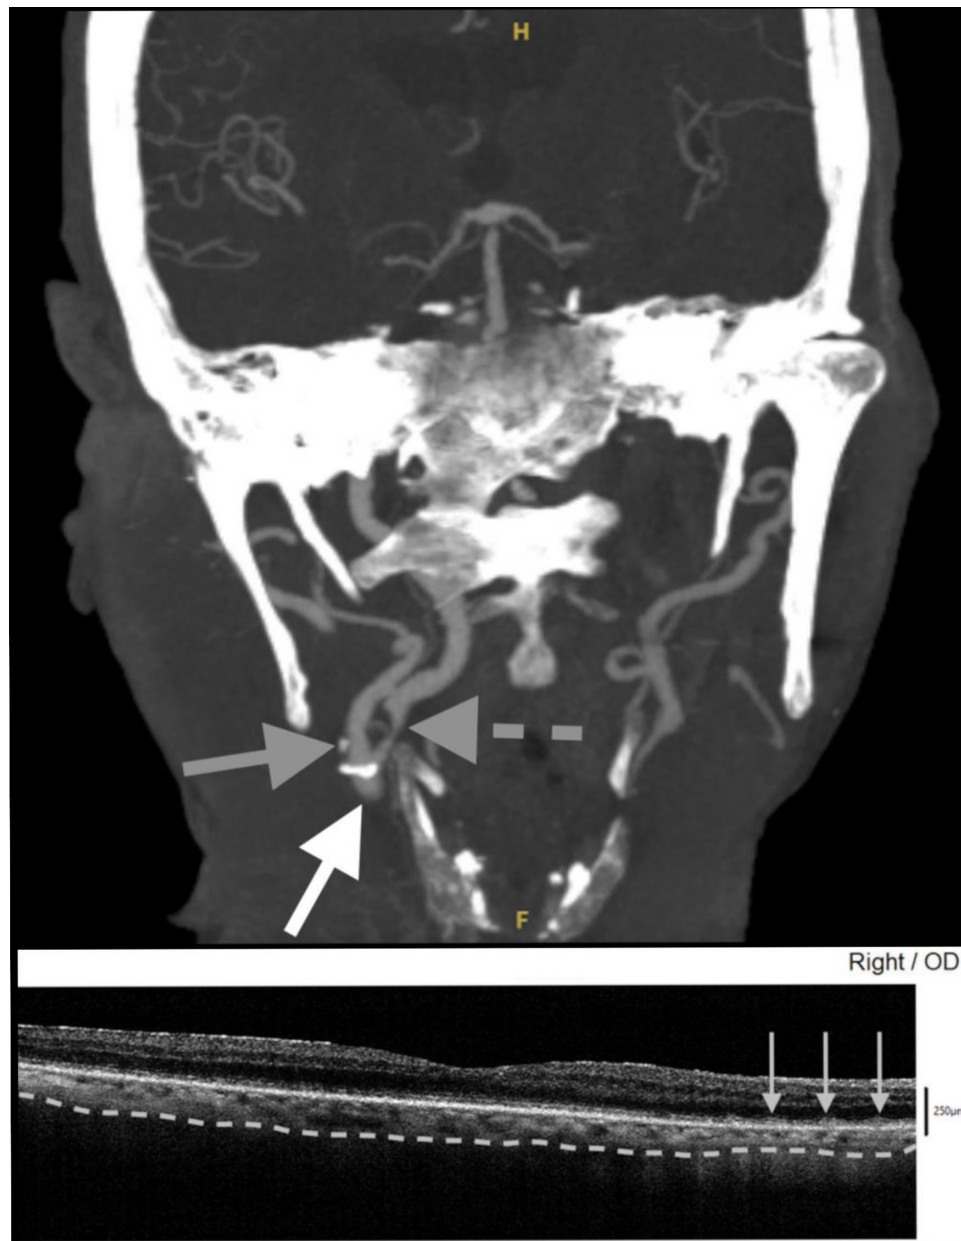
Top image:* CT angiography head and neck of a patient with bilateral ICA stenosis. Severe (70%–89%) right ICA stenosis is shown. Complete (100%) left ICA stenosis is demonstrated in another CT section (not shown). The right common carotid artery (*white arrow*) bifurcates into the right external carotid artery (*solid gray arrow*) and right ICA (*dashed gray arrow*). The *dashed arrow* points to the exact location of right ICA stenosis. Per neurovascular expert (M.D.), this image was windowed to distinguish between bone and contrast enhancement. Window width (WW) and window level (WL) were adjusted to 1133 and 395 Hounsfield units (HU), respectively. *Bottom image:* SD-OCT of the same patient's right eye demonstrating stage 2 and 3 SDDs (*gray arrows*), which elevate and penetrate the EZ. The interdigitation zone (IZ) is not visualized throughout and is replaced by granular material (stage 1 SDDs) in some places. The *gray dashed lines* demarcate the choroidal-scleral interface and demonstrate CTh (<250 μm). SD-OCT of this patient's left eye, not depicted, also showed stage 2 SDDs and choroidal thinning.
